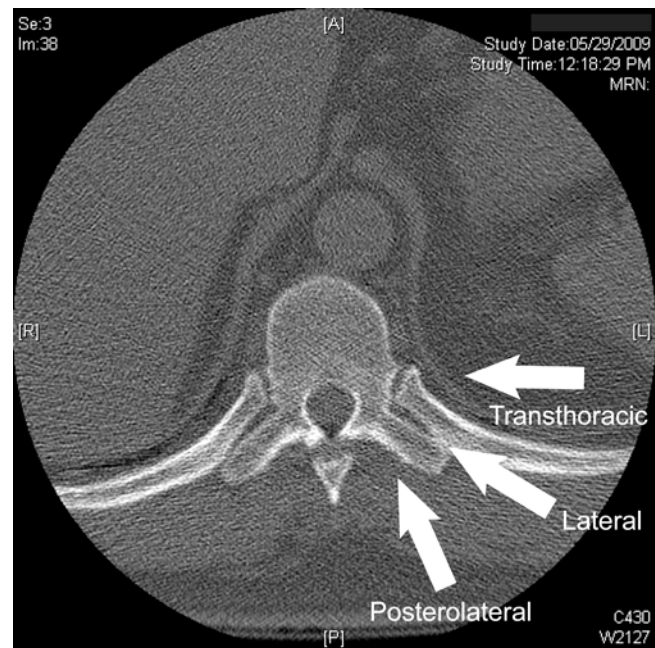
Approaches. The approaches available to treat thoracic herniated discs are the posterolateral (transpedicular, transfacet), lateral (costotransversectomy, lateral extracavitary), and transthoracic (thoracotomy, mini-open XLIF, thoracoscopic). The approach is tailored to the location, size, and calcification of the herniated disc
